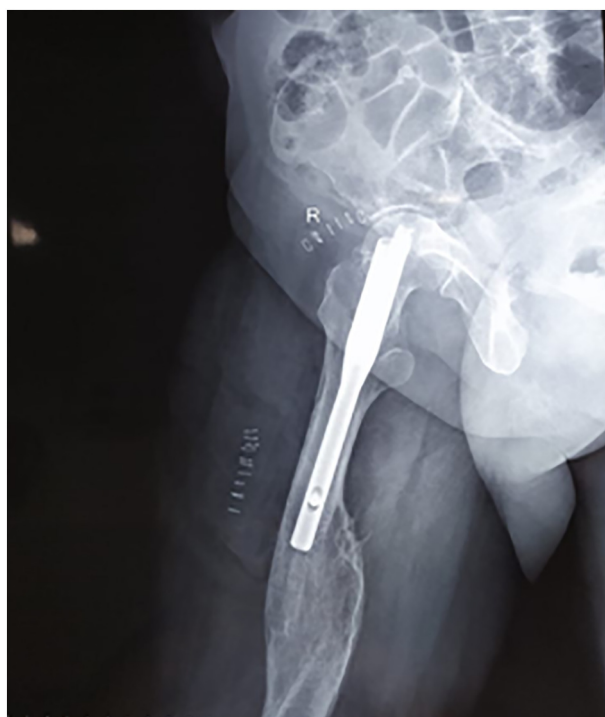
Post operative lateral radiograph with customised PFNA2 showing proper reduction and implant positioning.
